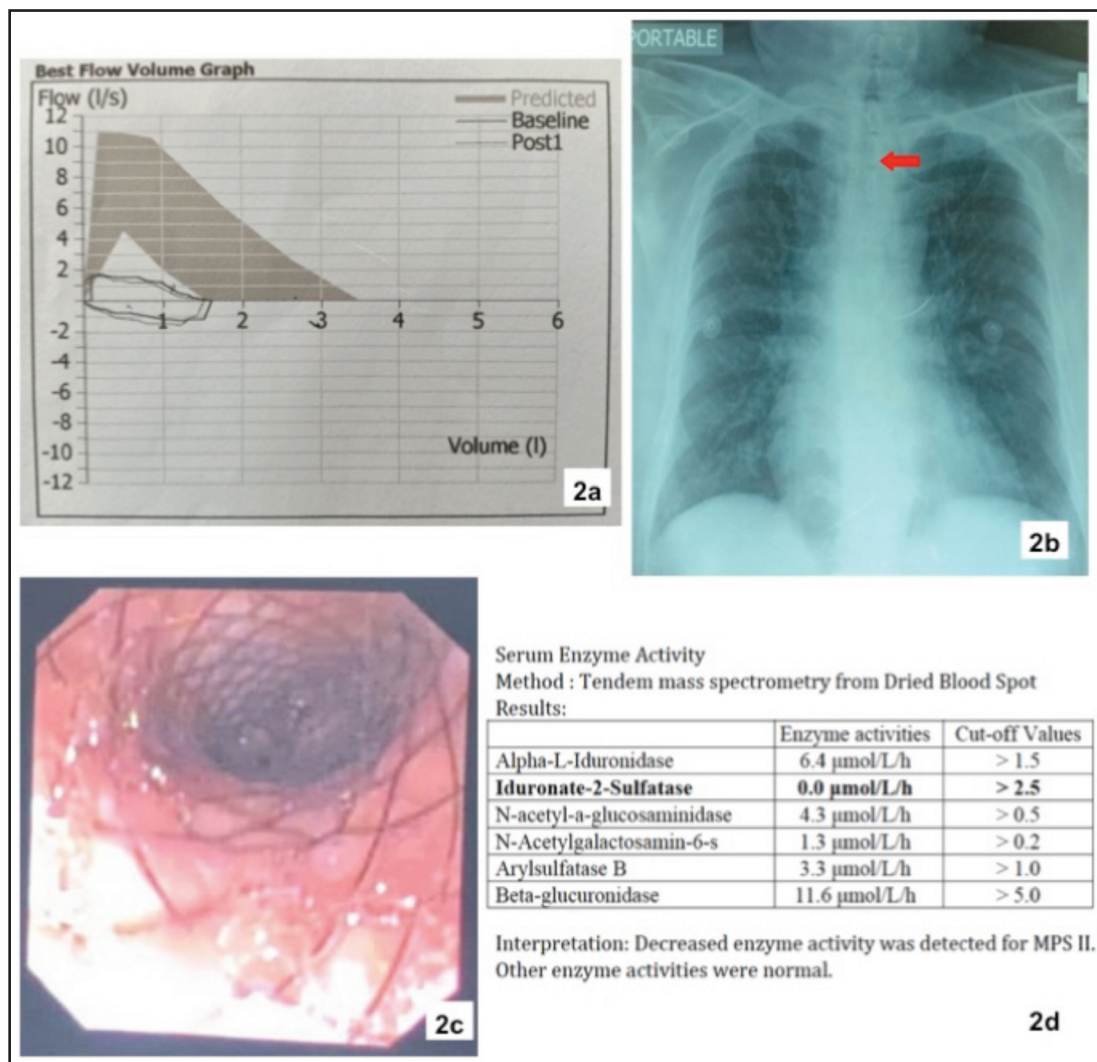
a) Plateau in both inspiratory and expiratory portion of the flow-volume loop indicates fixed airway obstruction. b) Chest x-ray post tracheal stenting shows stent in-situ (red arrow) with patent trachea. c) Post airway stenting with metallic stent revealed a patent trachea. d) Elevated urine GAG and absence of serum Iduronate-2-Sulfatase activity confirm the diagnosis of Hunter Syndrome. Other enzyme activities are normal.
